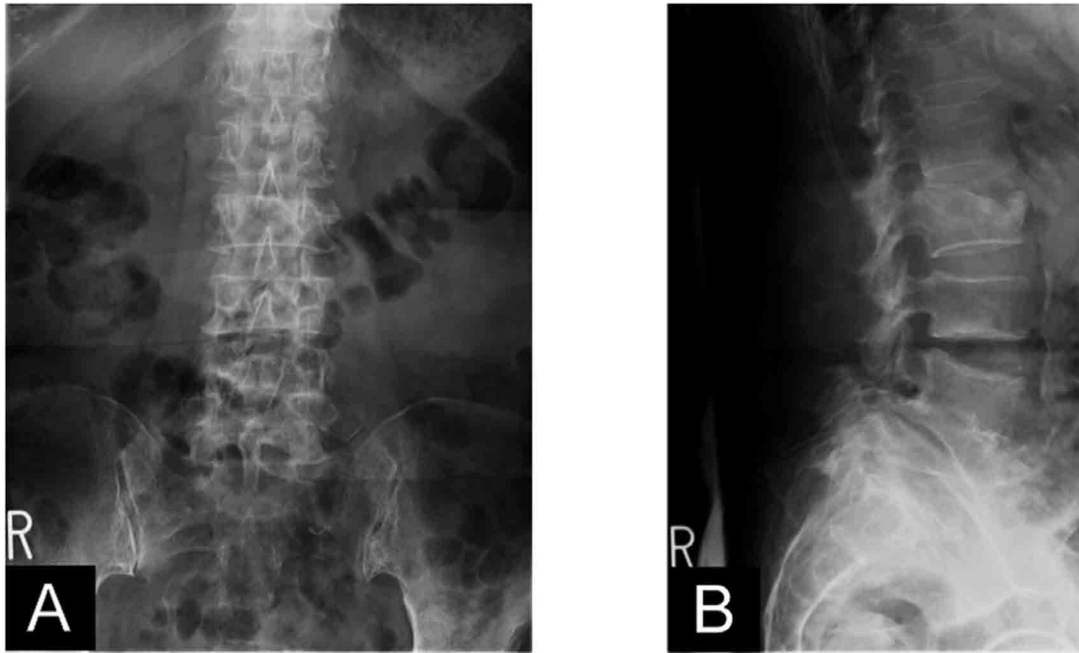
Anteroposterior (A) and lateral (B) radiographs. Spondylolisthesis (natural fusion) at L4/5 and old lumbar compression fractures at L2, L3, and L4 were observed.
